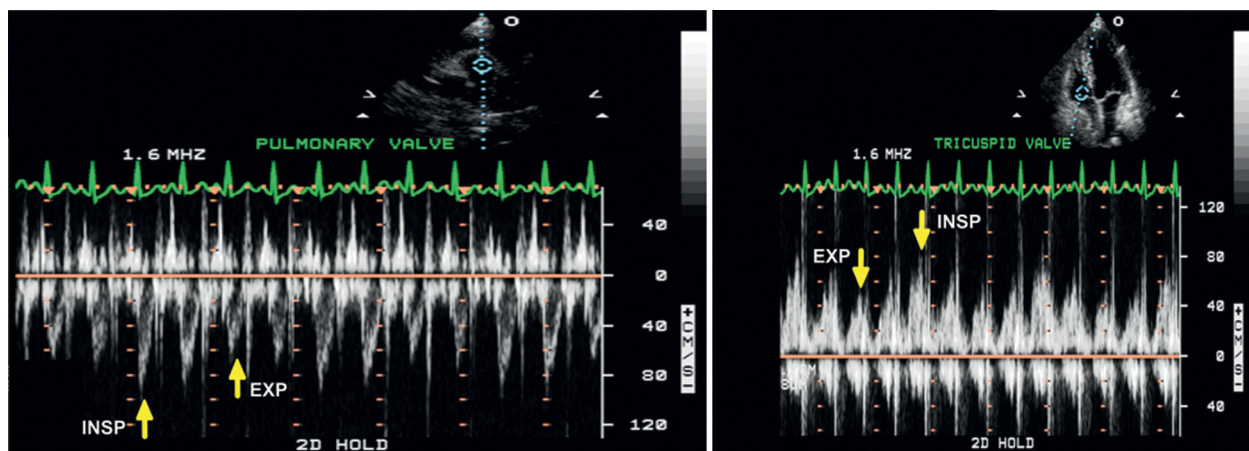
Doppler spectra showing the characteristic exaggerated respiratory variation in outflow (left panel) and inflow (right panel) Doppler spectra. On inspiration, right-sided flow increases with corresponding reductions in left-sided flow. EXP = expiration; INSP = inspiration.
